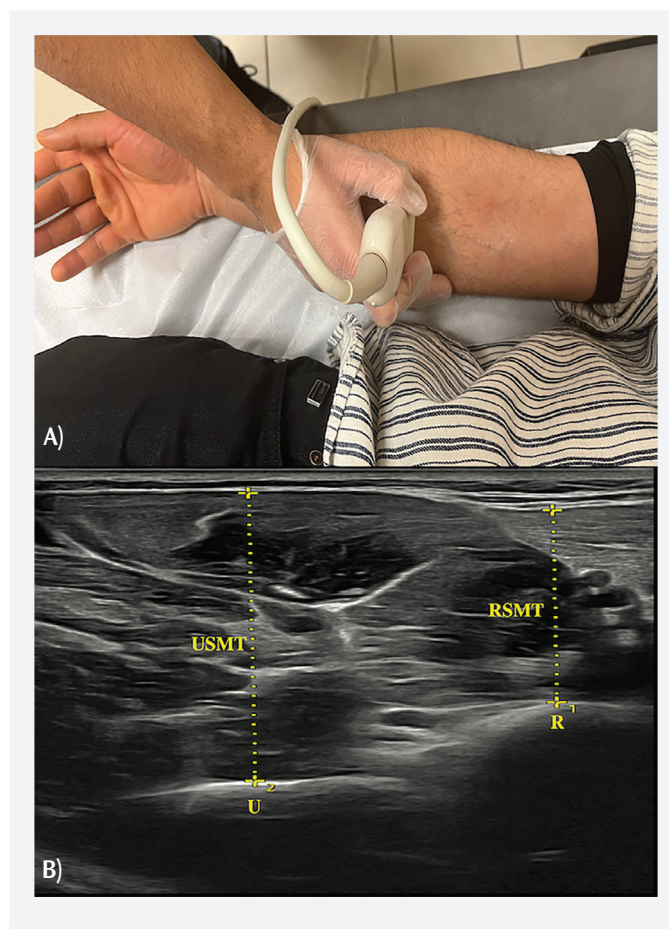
Images of the ultrasound scanning protocol
